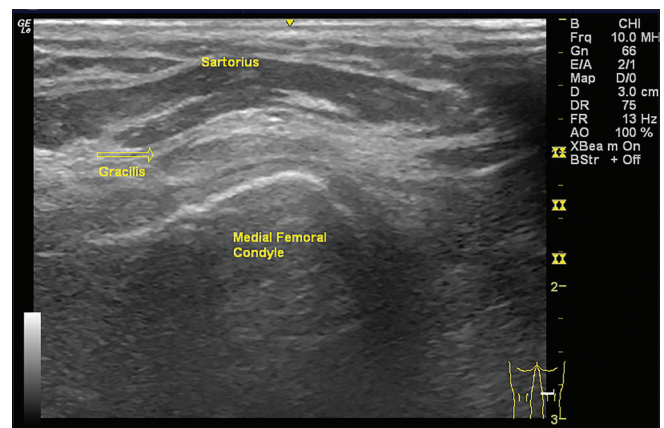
Transverse ultrasound of gracilis tendon anterior to medial condyle – Case 1. A 31-year-old male with right knee pain. Transverse sonogram showing the gracilis tendon in knee extension after snapping over the medial femoral condyle. The dynamic ultrasound of this image is demonstrated in Supplemental Video 1.
